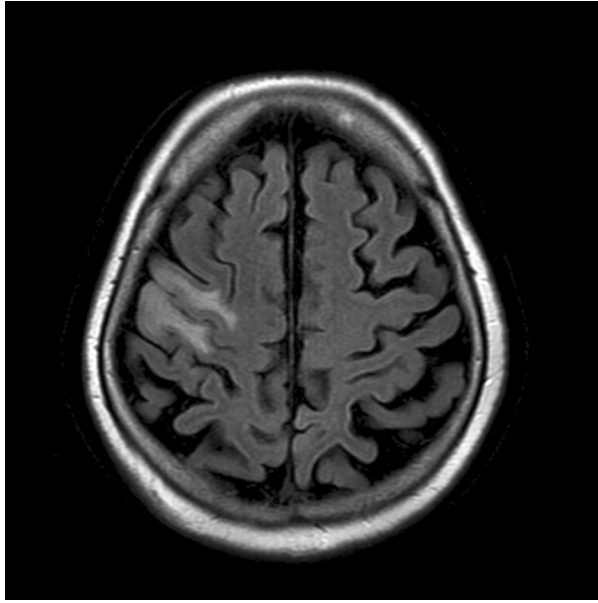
Fluid-attenuated inversion recovery MRI in a woman with epilepsy partialis continua, Hu antibody in serum and small cell lung cancer.
